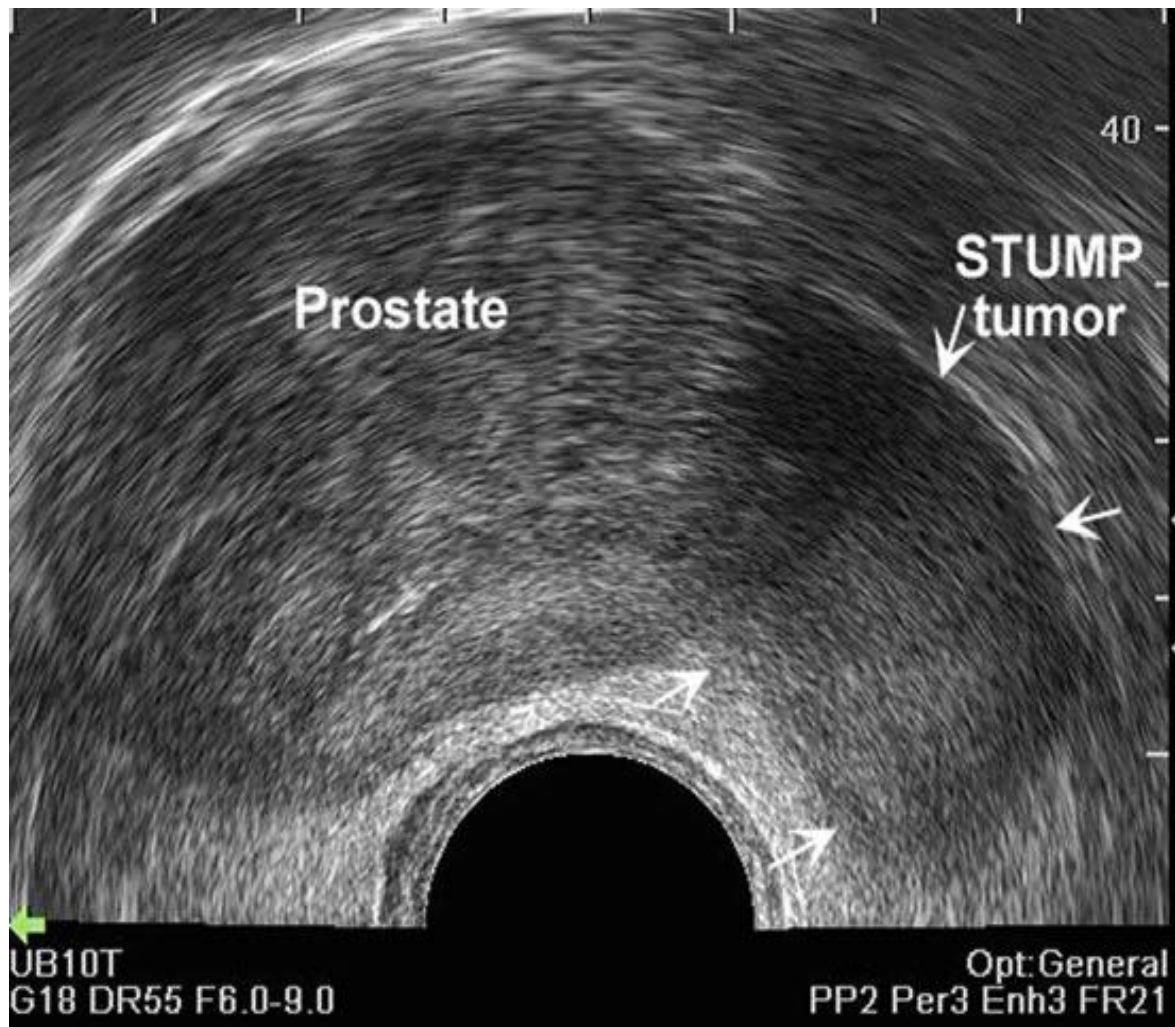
b. An axial sonogram of the prostate reveals a hypoechoic solid mass adjoining the gland's left lateral margin, confirmed as a stromal tumor (1).
